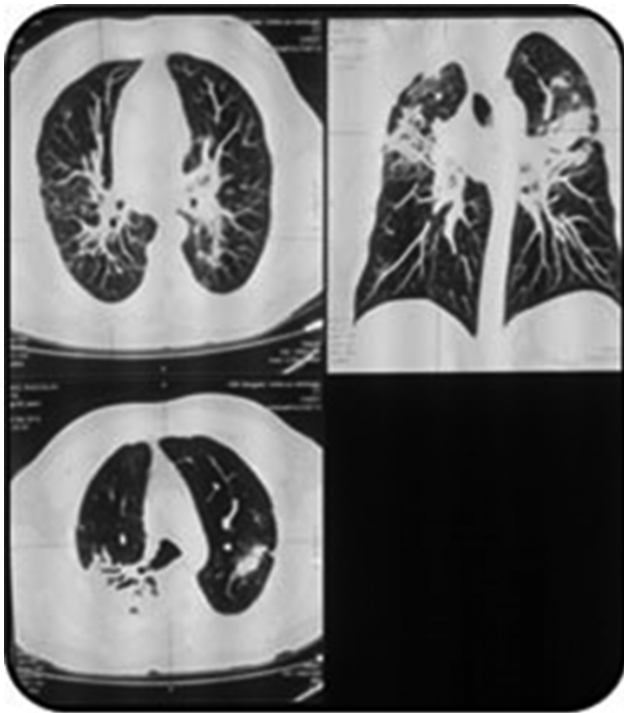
CT scan of thorax, made in 2010. It showed progression of lung lesions with mediastinal lymphadenopathy which suggested chronic sarcoidosis
